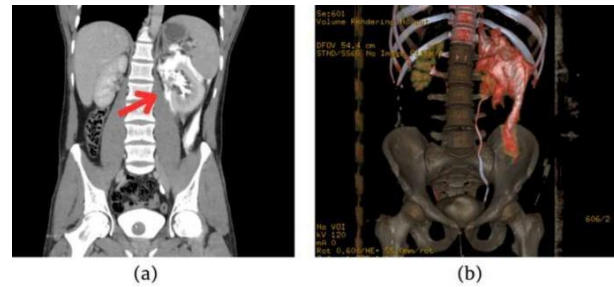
Coronal image (a) and VR reconstruction (b) of the contrast-enhanced CT scan in the delayed phase showing contrast extravasation (arrow).
